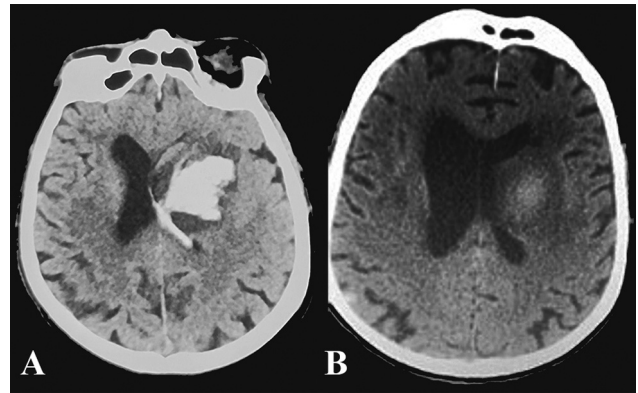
(A) A noncontrast head computed tomography (CT) shows an acute deep cerebral hemorrhage in the left basal ganglia with surrounding vasogenic edema, followed by an intraventricular hemorrhage with no midsagittal plane shift. (B) The follow-up CT scan showed significant resorption of the basal ganglia hematoma.
